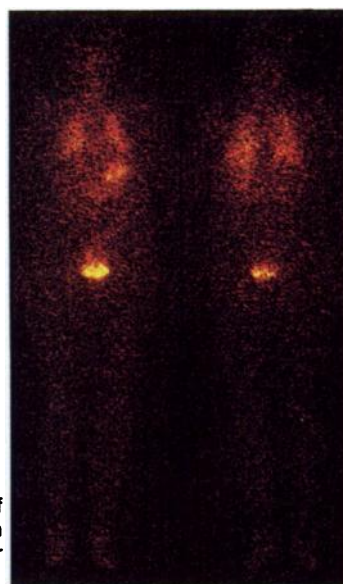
Whole-body scintigram of volunteer A. B. at 3 hr after inhalation of ^{123}I -IFNg (100 µg). Left, anterior view; right, posterior view.
